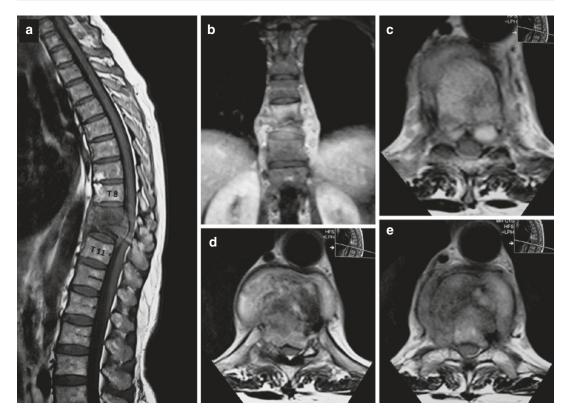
T9–T10 Pott's disease. Spinal MRI on T1-weighted image after gadolinium administration, sagittal (a), coronal (b) and axial views (c–e)
